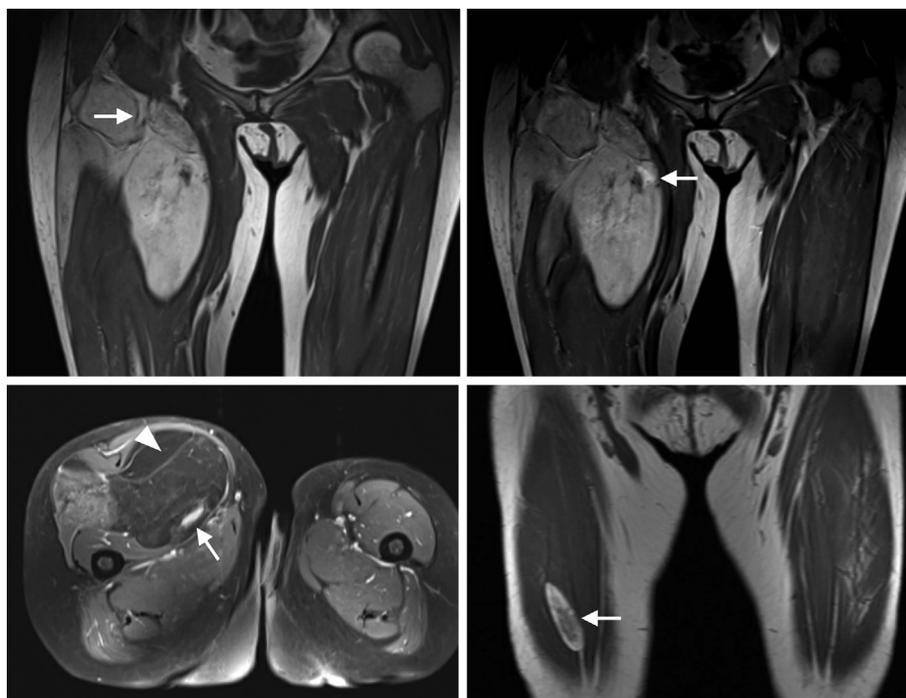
Representative features of ALT on MRI employed in this study. (Left above) The arrow indicates thick septum (>2 mm) in a coronary T1-weighted image. (Right above) The arrow indicates a nodular contrast-enhanced area (>1 cm). (Left below) The arrow indicates a nodular contrast-enhanced area (>1 cm) and the arrowhead shows a thick septum (>2 mm) in an axial T1-weighted and contrast-enhanced fat-suppression T1-weighted image. (Right below) The arrow indicates less than 75% fat component in a coronary T1-weighted image.
